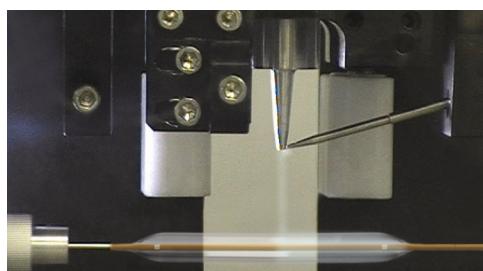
Ultrasonic Atomizing Nozzle Spraying Onto a DEB
